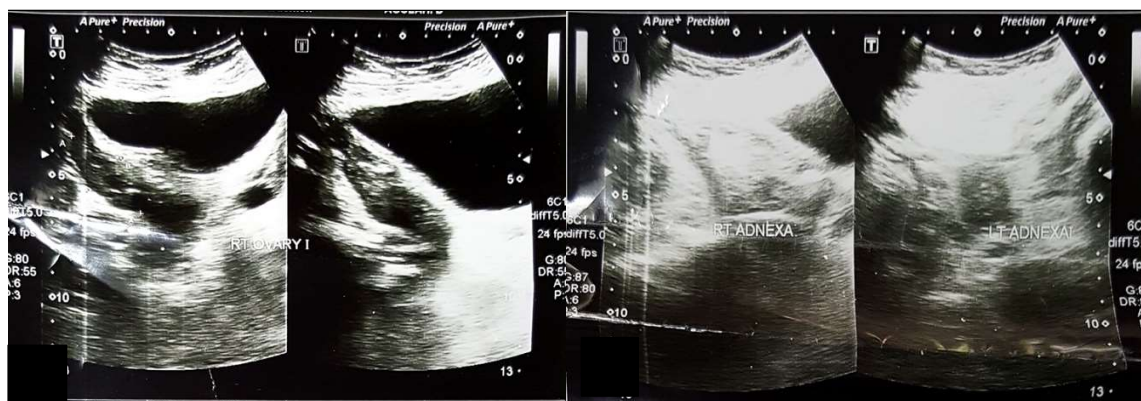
A and B: Ultrasound scan images demonstrating the left and right adnexa, respectively.
